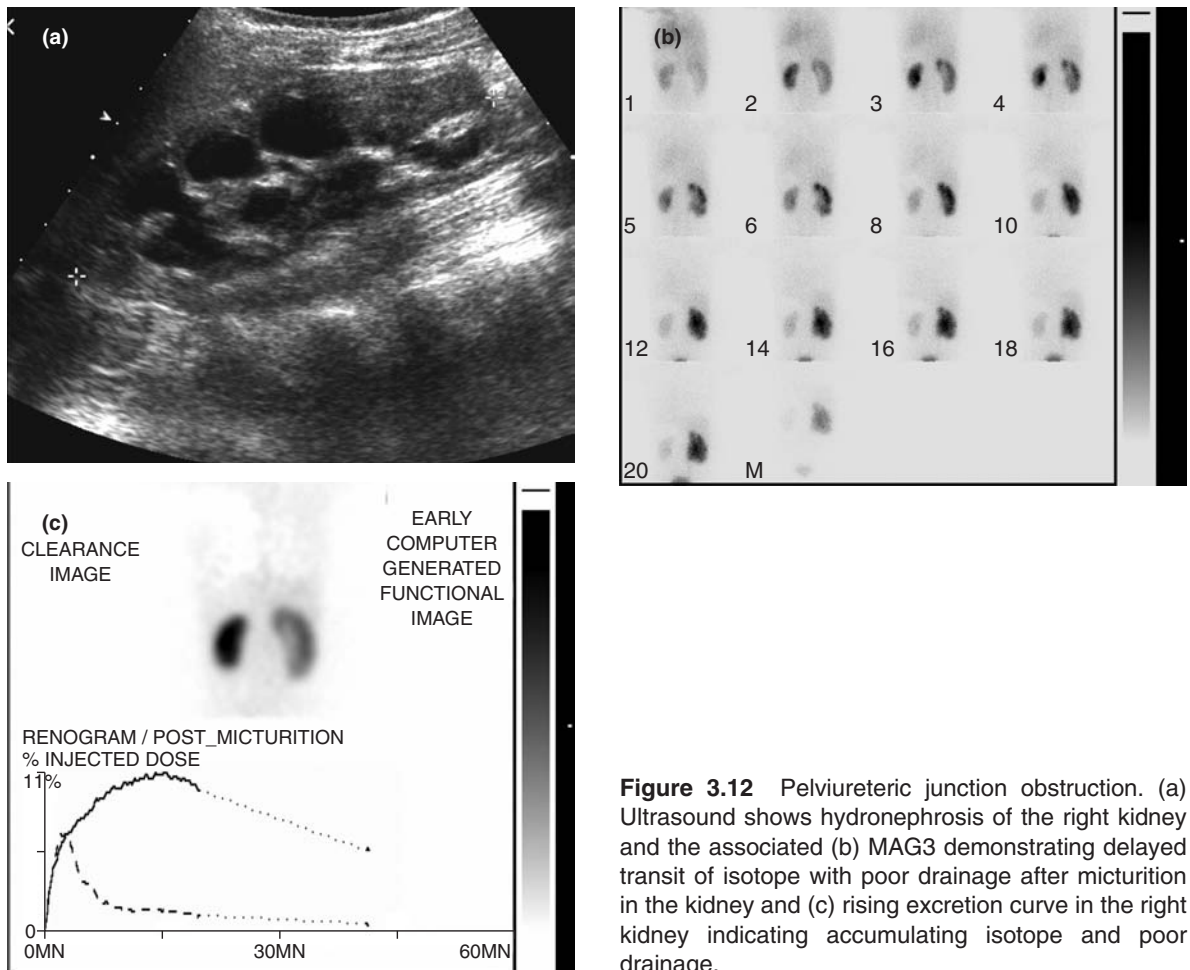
Pelviureteric junction obstruction. (a) Ultrasound shows hydronephrosis of the right kidney and the associated (b) MAG3 demonstrating delayed transit of isotope with poor drainage after micturition in the kidney and (c) rising excretion curve in the right kidney indicating accumulating isotope and poor drainage.
